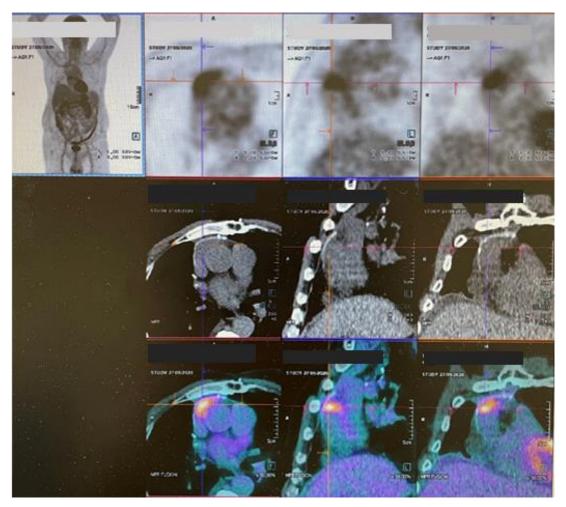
FDG-PET images show uptake in the anterior mediastinum (SUV max of 5.3) located next to the ascending aorta.
